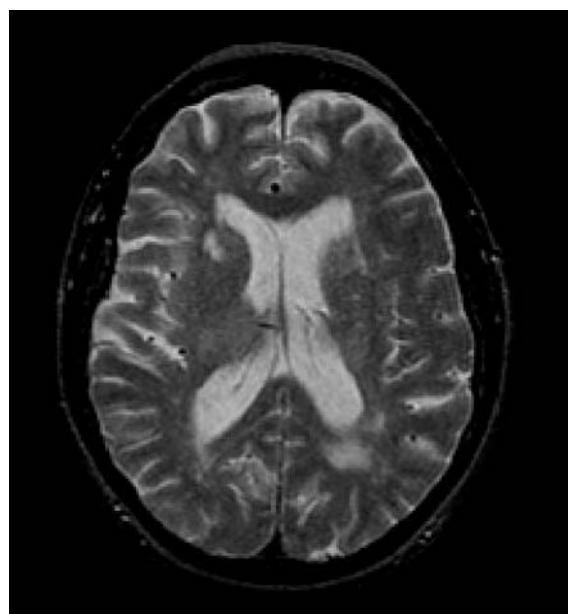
MRI in NPSLE. This T2-weighted MRI demonstrates cortical atrophy, ventricular dilation, small focal white matter lesions, and deep white matter lesions, typical of NPSLE.
